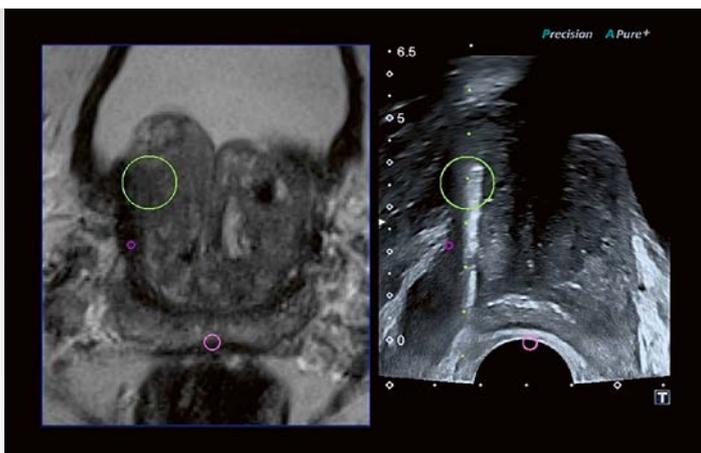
MRI-US fusion guided biopsy. Left image: MRI, T2w axial. Right image: Realtime US image with biopsy.
